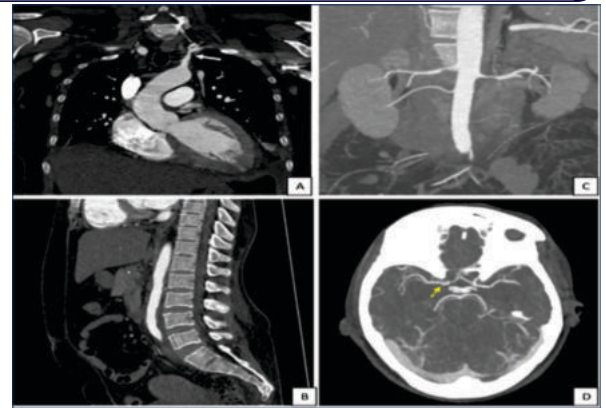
A) Coronal MIP CT image showing short segment circumferential wall thickening with luminal narrowing in proximal left subclavian artery. B) Sagittal MIP CT image showing circumferential symmetric hypodense wall thickening in infra renal abdominal aorta causing mild luminal narrowing. C) Coronal MIP CT image of abdominal aorta showing short segment areas of luminal narrowing in bilateral proximal renal arteries. Accessory right renal artery is noted supplying lower pole of right kidney. D) Axial MIP CT image showing irregular outline of M1 segment of right MCA (yellow arrow)-beaded appearance
